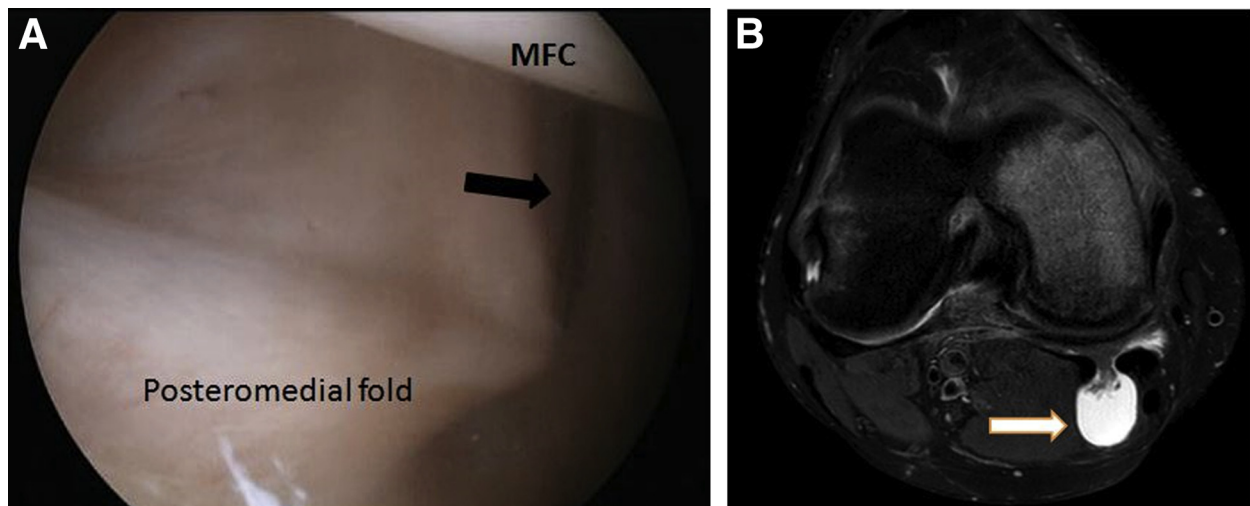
Arthroscopic view from the anterolateral viewing portal in the right knee: transnotch maneuver. (A) Entrance to the popliteal cyst cannot be identified in the posteromedial capsule with a needle (black arrow) introduced through the skin, but (B) existence of the cyst is confirmed on magnetic resonance imaging scans. (MFC, medial femoral condyle.)
